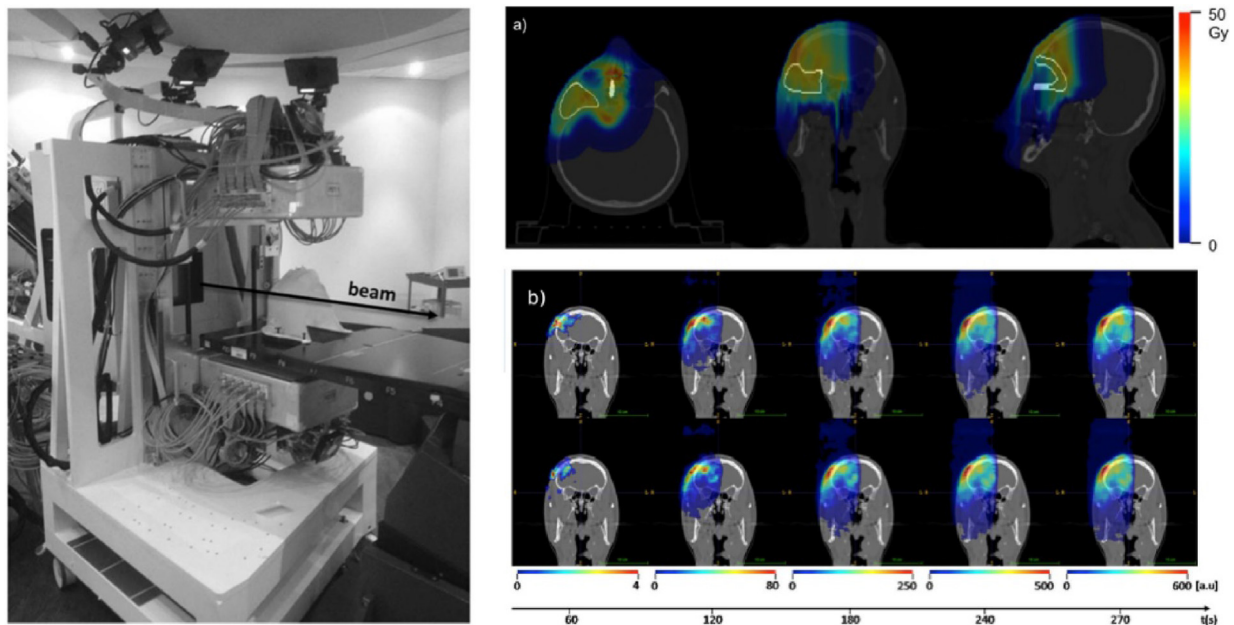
Left: The INSIDE in-beam dual-head PET scanner at CNAO, resting on a mobile support placed between the horizontal beam line nozzle (with beam direction indicated by an arrow) and the patient couch. Right: a) Proton treatment plan displaying the colour-coded dose overlaid on different views of the patient CT, indicating the clinical target volume in white. b) Time evolution of the colour-coded irradiation induced activity, shown in a 2D slice again superimposed to the planning CT for two different treatment fractions (top and bottom row). Taken from [26].
